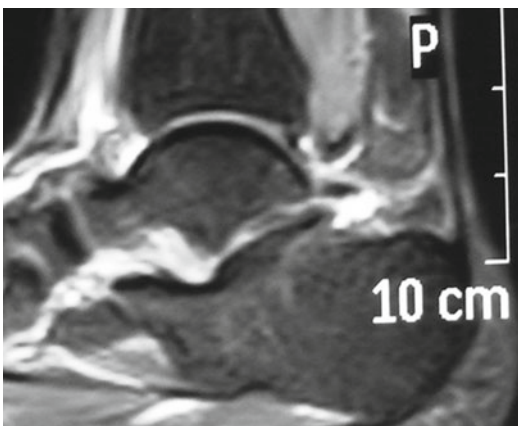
MR image of an os trigonum with bone edema and posterior ankle synovitis
